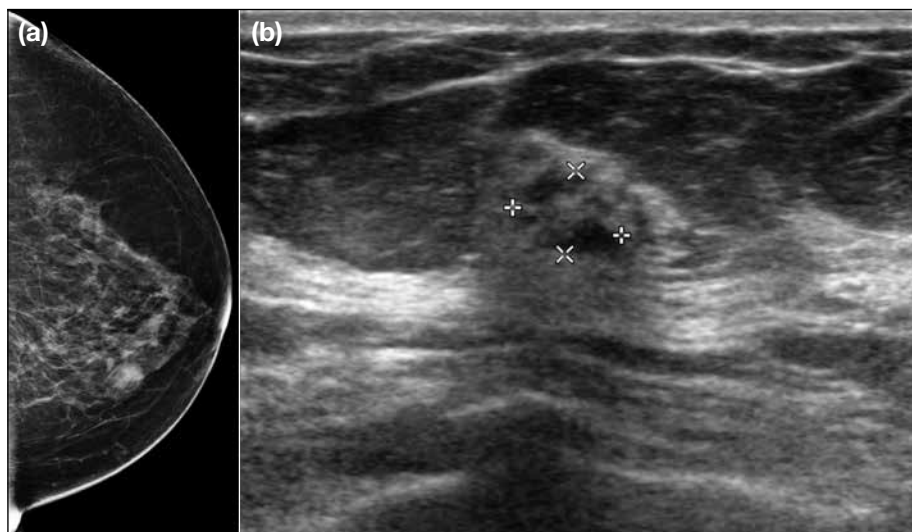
(a) Left craniocaudal mammogram of a 61-year-old woman with prior right breast conservation therapy for right breast cancer shows an oval circumscribed equal density lesion at the inner quadrant. (b) Ultrasonogram showing a lesion of mixed echogenicity at the corresponding location. It was classified as low suspicious. Biopsy showed focal fibrosis. She is pending interval follow-up mammography and ultrasonography.
